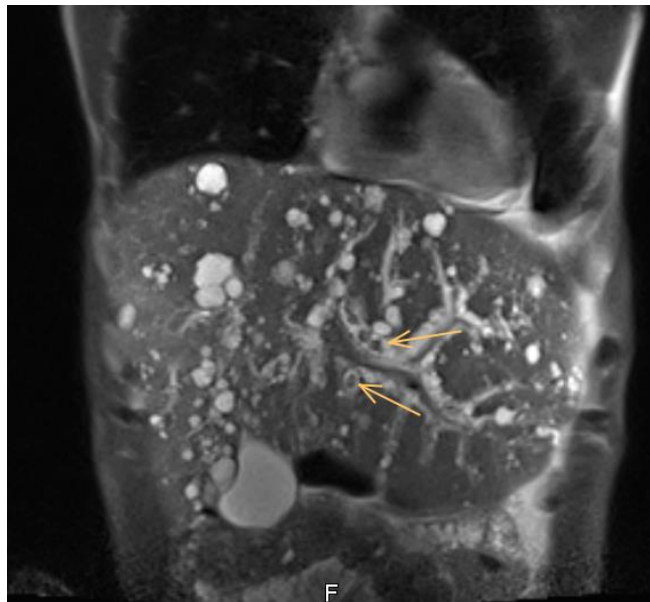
Liver MRI in coronal sequence revealing multiple cystic formations of the liver with dilated intrahepatic bile ducts and intrahepatic stones (arrows)
